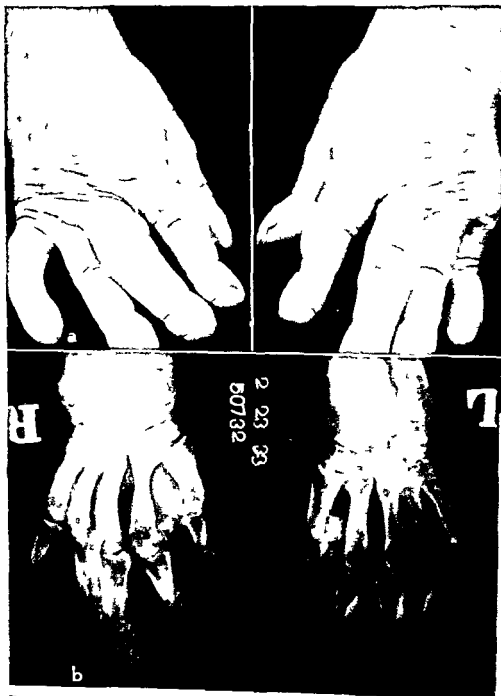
Pulmonary hypertrophic osteoarthropathy. Case M. W. a) Note clubbing of the end phalanges. b) X-ray shows advanced hypertrophic changes.
